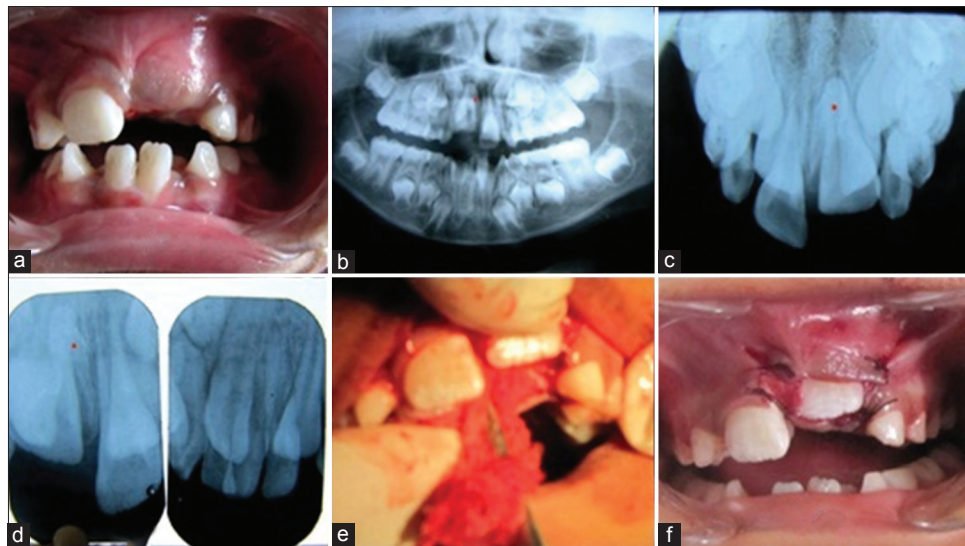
(a) Unerupted left central incisor (b) Orthopantomograph showing the supernumerary teeth (c) Occlusal view, (d) Intra-oral periapical radiograph (e) Surgical exposure of central incisor (f) Post-operative
